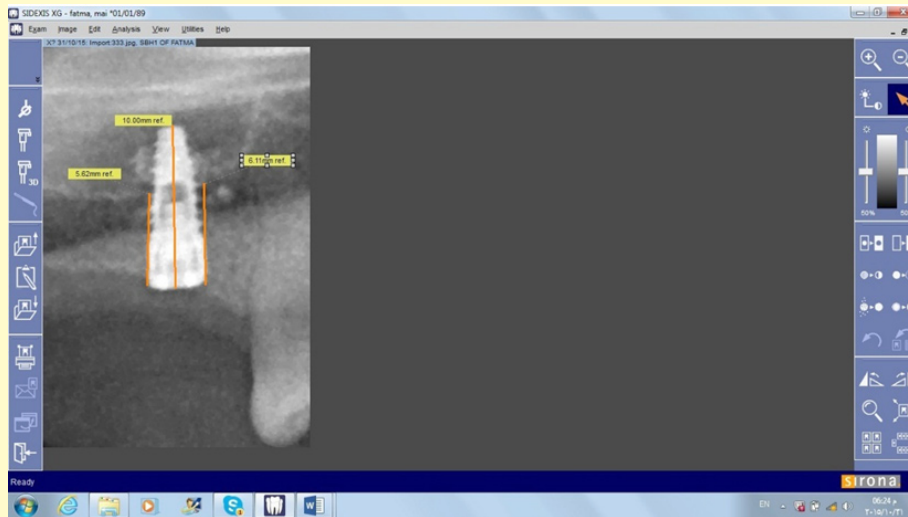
Radiographic picture showing the calculation of SBH1.
